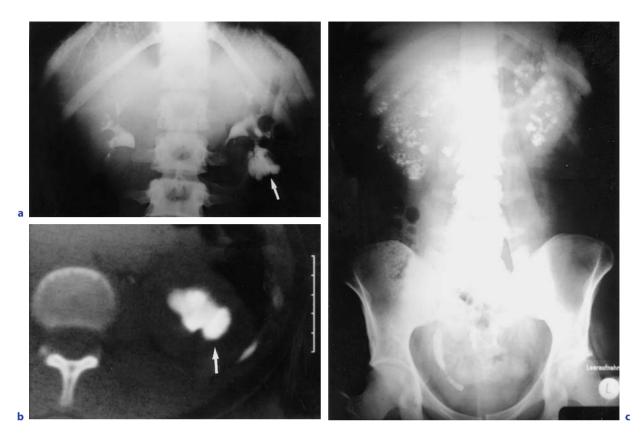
MSK: a IVU of a segmental MSK (arrow) in a child, with corresponding late phase CT image (b). c Plain film of severe diffuse disease with bilateral clotty medullary calcifications and distal ureteral calculi in an adolescent patient
